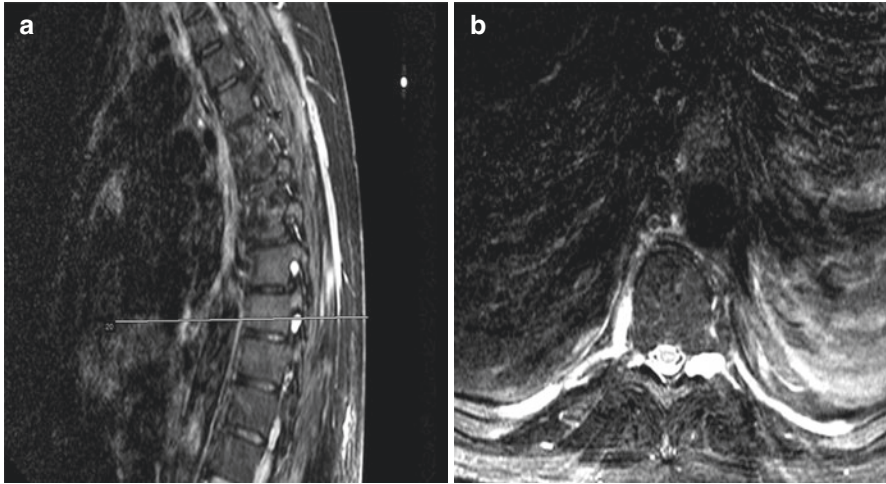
T2-weighted imaging of the spine. Sagittal (a) and axial (b) imaging showing a perineural cyst
